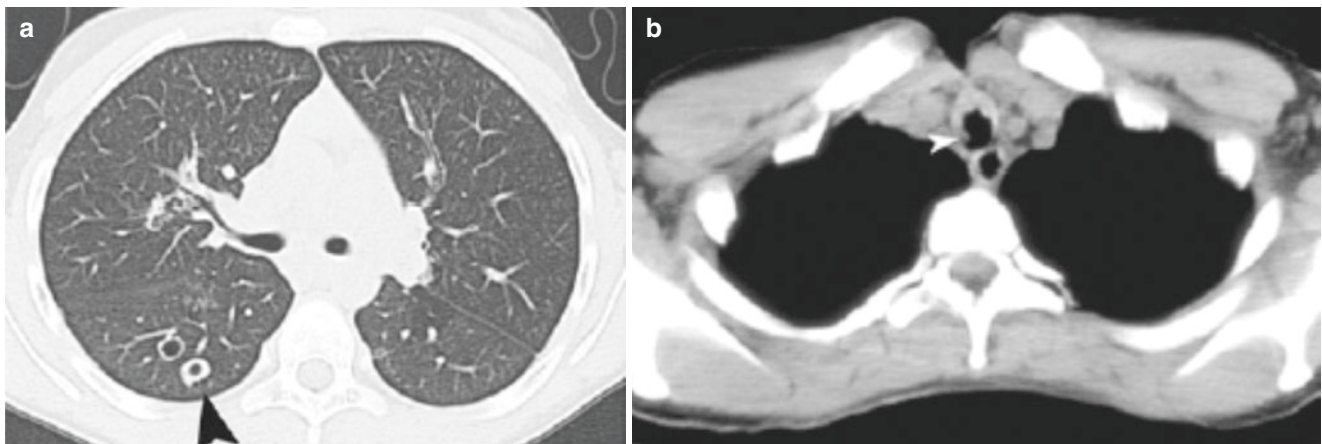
Eleven-year-old girl with history of multiple surgical procedures for laryngotracheal papillomatosis. (a) Axial lung window CT image shows thin- and thick-walled pulmonary nodules (arrowhead).
